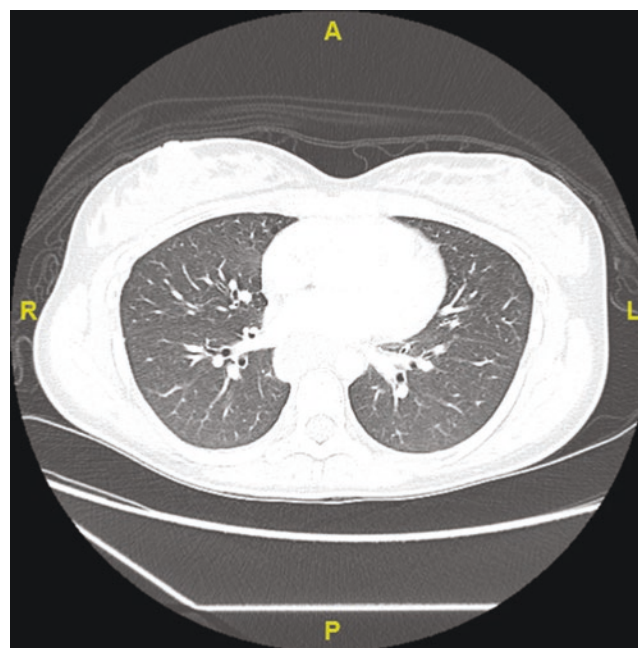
Chest CT showing diffuse patchy infiltrates, most prominent in the para-hilar region, with associated lymphadenopathy
